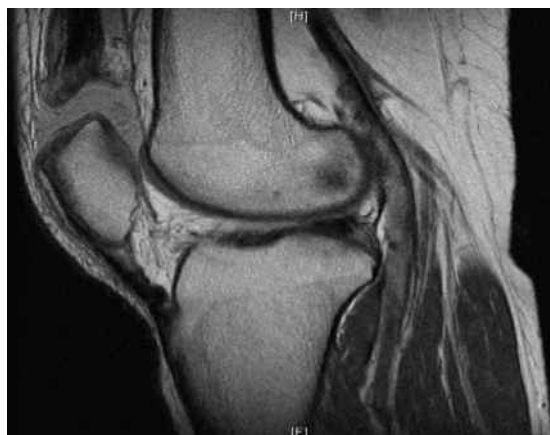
Sagittal PD-W MR image of the left knee shows a complete tear of the quadriceps tendon.
